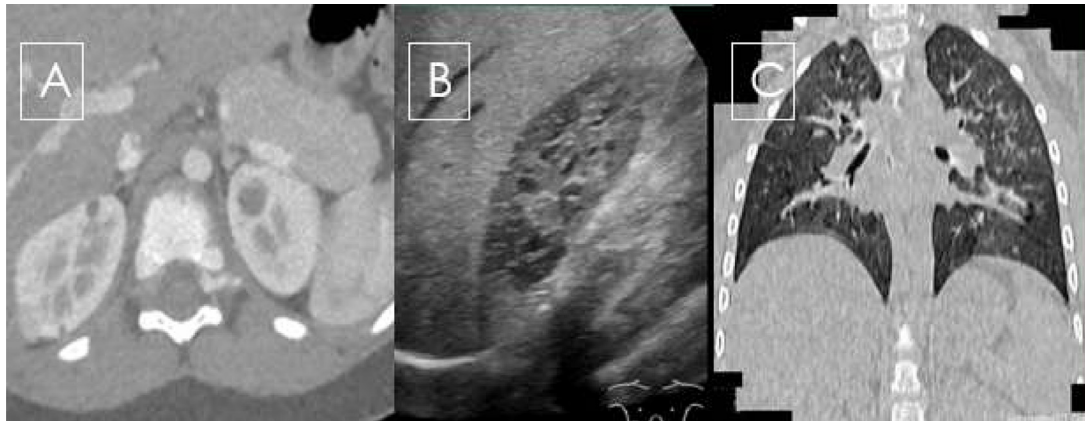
(A and B) Contrast-enhanced CT scan showing 1–2 small hypodense nodules in the kidneys. Ultrasound of the kidney showed multiple focal hyperechoic small lesions measuring less than 5mm. These lesions were spread in both the kidneys, predominantly on the right kidney, suggesting angiomyolipoma (AML). (C) Coronal chest CT scan showing multiple small, thin-walled pulmonary cysts in both lungs, suggesting LAM or MMPH of the lungs (lymphangiomyomatosis).
